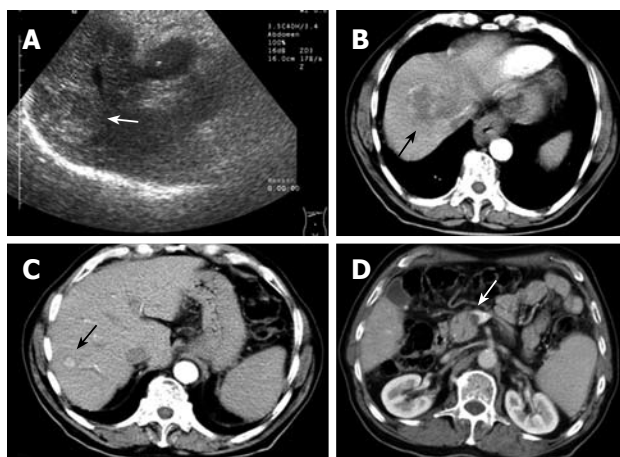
Liver sonography (A) and CT imaging of hepatocellular carcinoma (HCC) (B-D). A: Round but inhomogeneous tumor with hyper- and hypo-echoic appearance in the sonography (diameter 6 cm, arrow); B: Axial multidetector CT contrast image at the arterial phase demonstrated a tumor lesion in the right upper lobe (arrow). Dimension 7 cm × 6.5 cm × 60 cm with hyperdense periphery and hypodense centre (latter areas of necrosis); C: Additional 1.4 cm × 1 cm × 1 cm hyperintense lesion in segment VII of the liver (arrow); D: Partial thrombosis of the portal vein (arrow).
